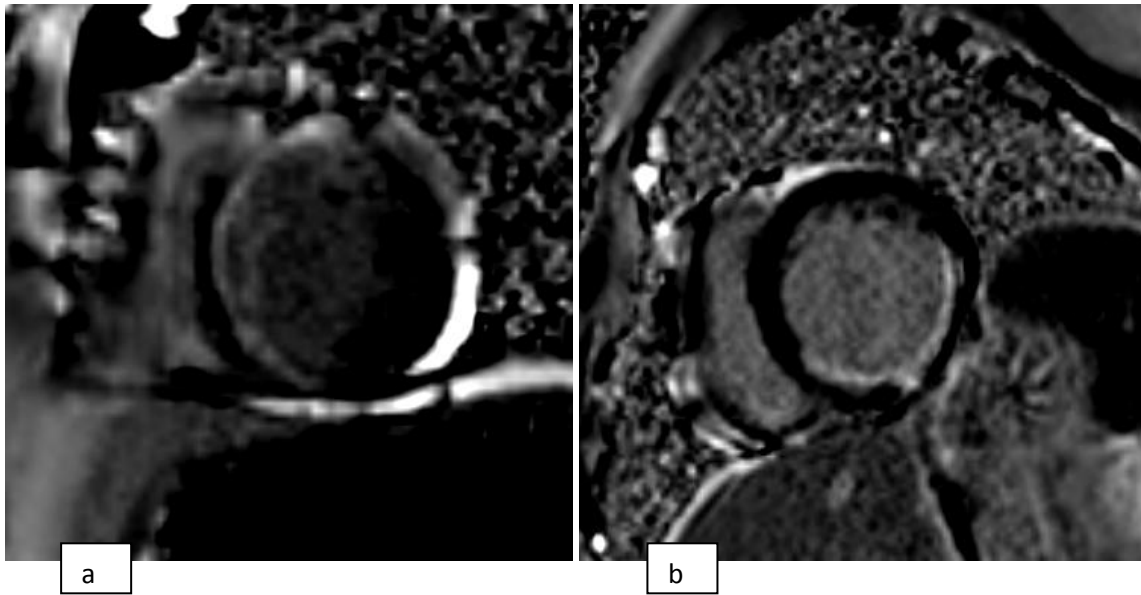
a,b,c : Cine sections, MRI PSIR sequence showing infarct in the myocardium involving 26 to 50% of the wall thickness in the LAD and RCA territory
